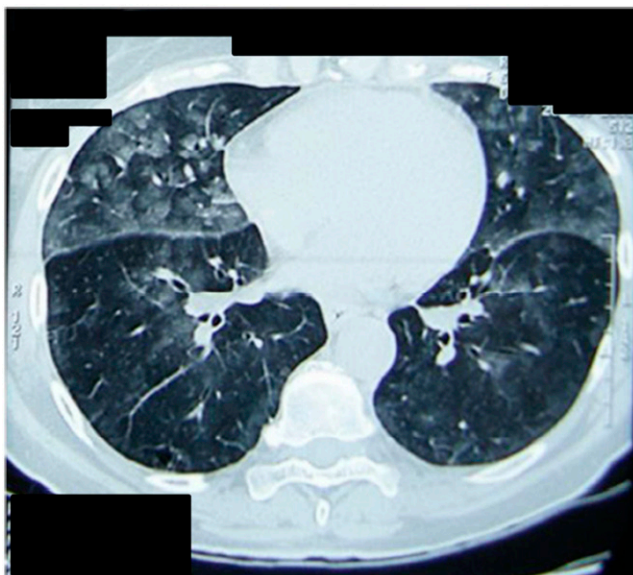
Thoracic computed tomography characteristic of IPE.
